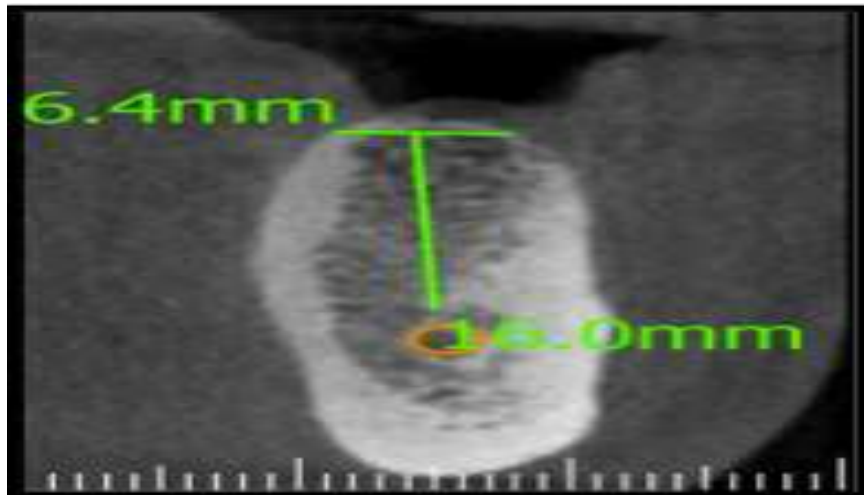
Pre-operative CBCT, Cross section, 46 Region
